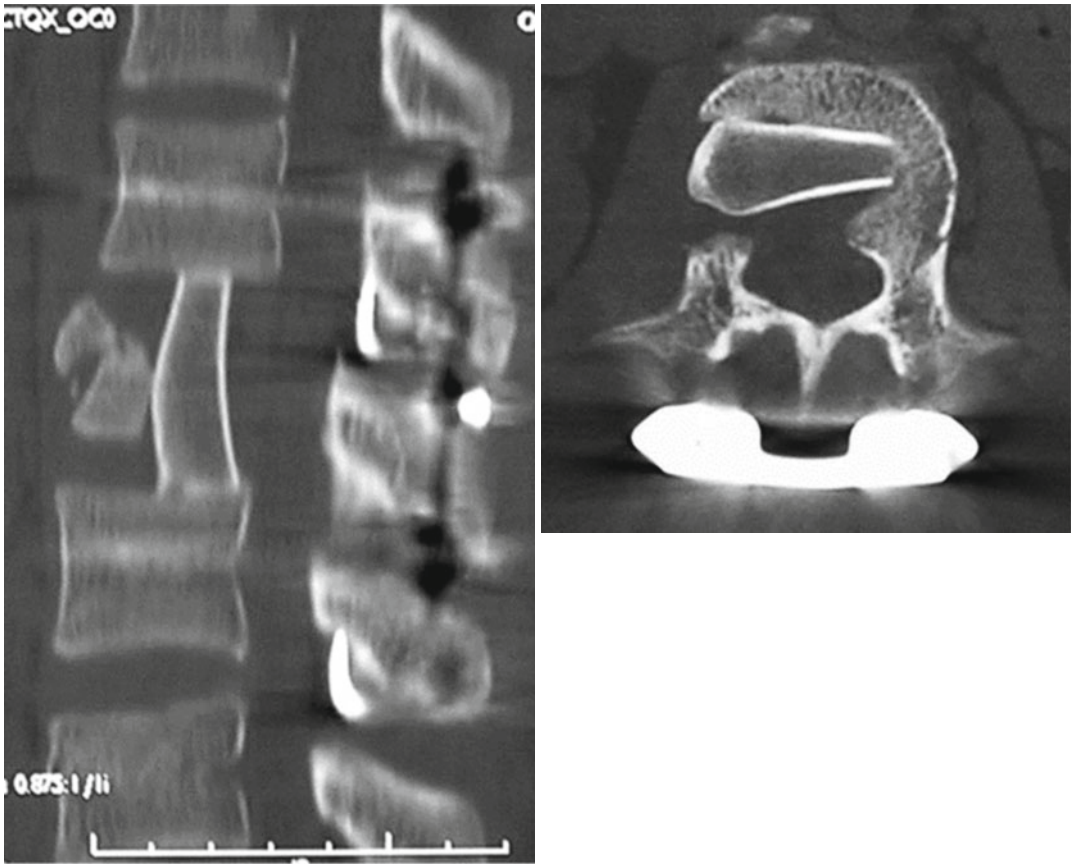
Postoperative sagittal and axial CT scans 1 year after surgery
